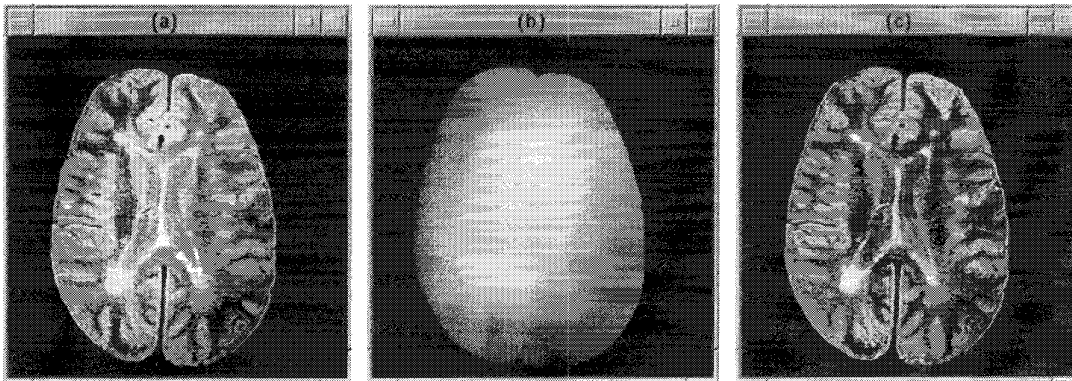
PD-weighted image data of slice 16 of MRI data set 2 (a) before and (b) after (c) RF-correction. (b) shows the detected RF inhomogeneity, (a)/(c).
